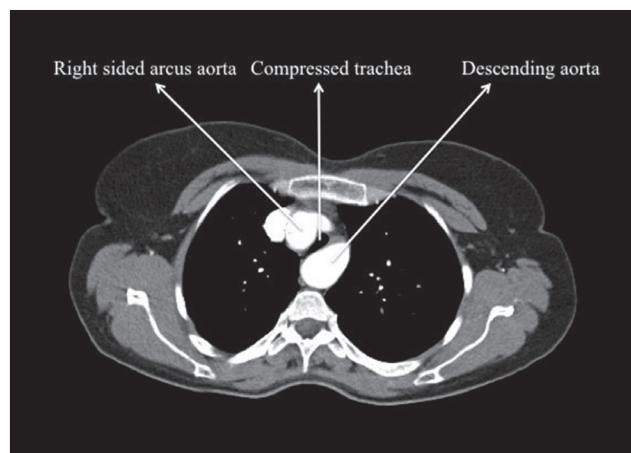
Computed tomography of the thorax, compressed tracheal lumen is shown.
